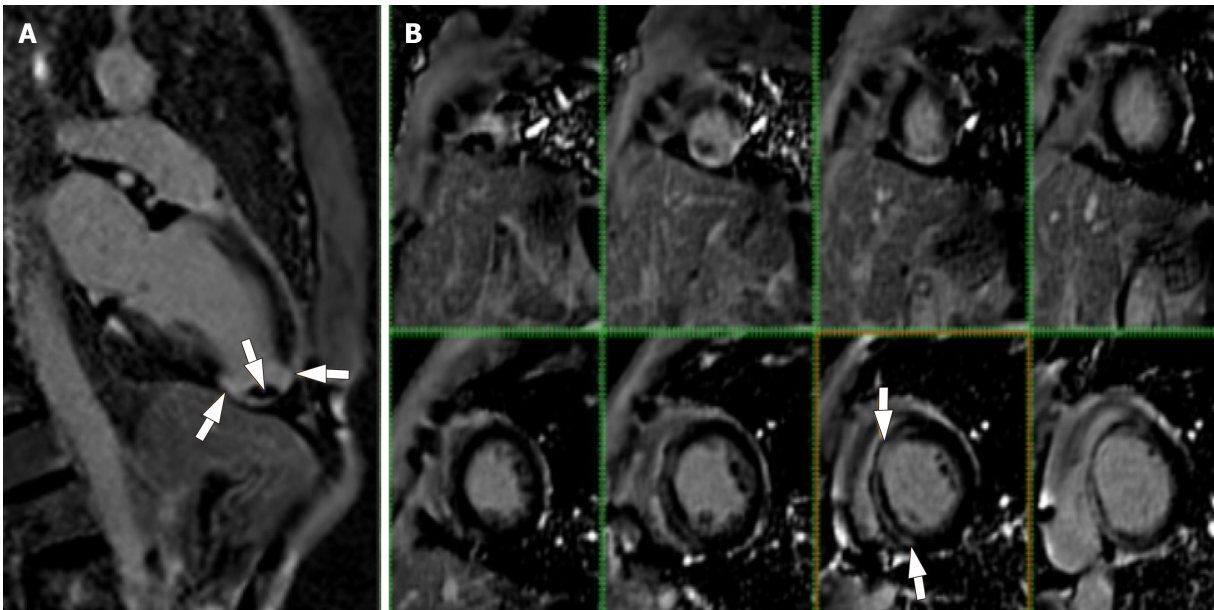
Cardiac magnetic resonance imaging of a patient with stage B1 Chagas heart disease. A: Myocardial delayed enhancement on 2-chamber apical slice depicts areas of cardiac fibrosis in the apical segments and an apical thrombus; B: Myocardial delayed enhancement protocol on left ventricular short-axis slices depicts areas of cardiac fibrosis in the apical and basal left ventricular walls of a patient at stage B1 of Chagas heart disease.
